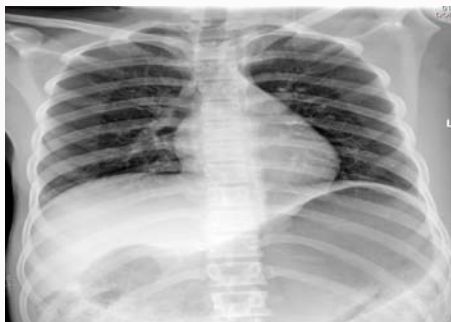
Supine Chest X-ray of the patient at presentation.
